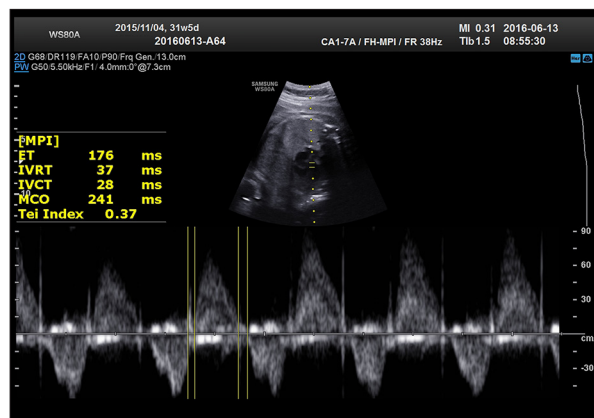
Normal myocardial performance index Doppler tracing at the mitral valve.
